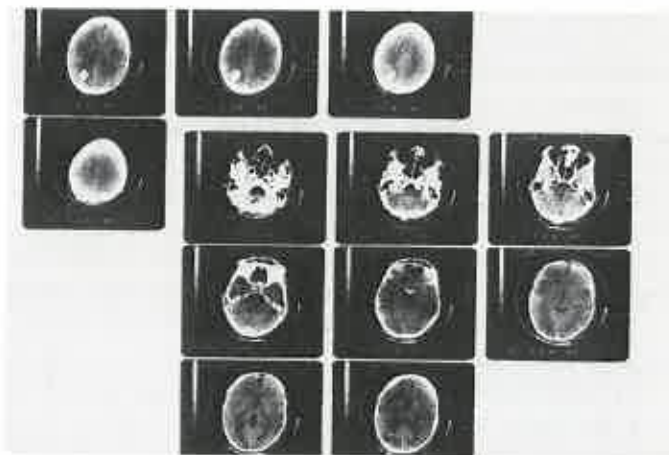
CT Scan – intracerebral hematoma
